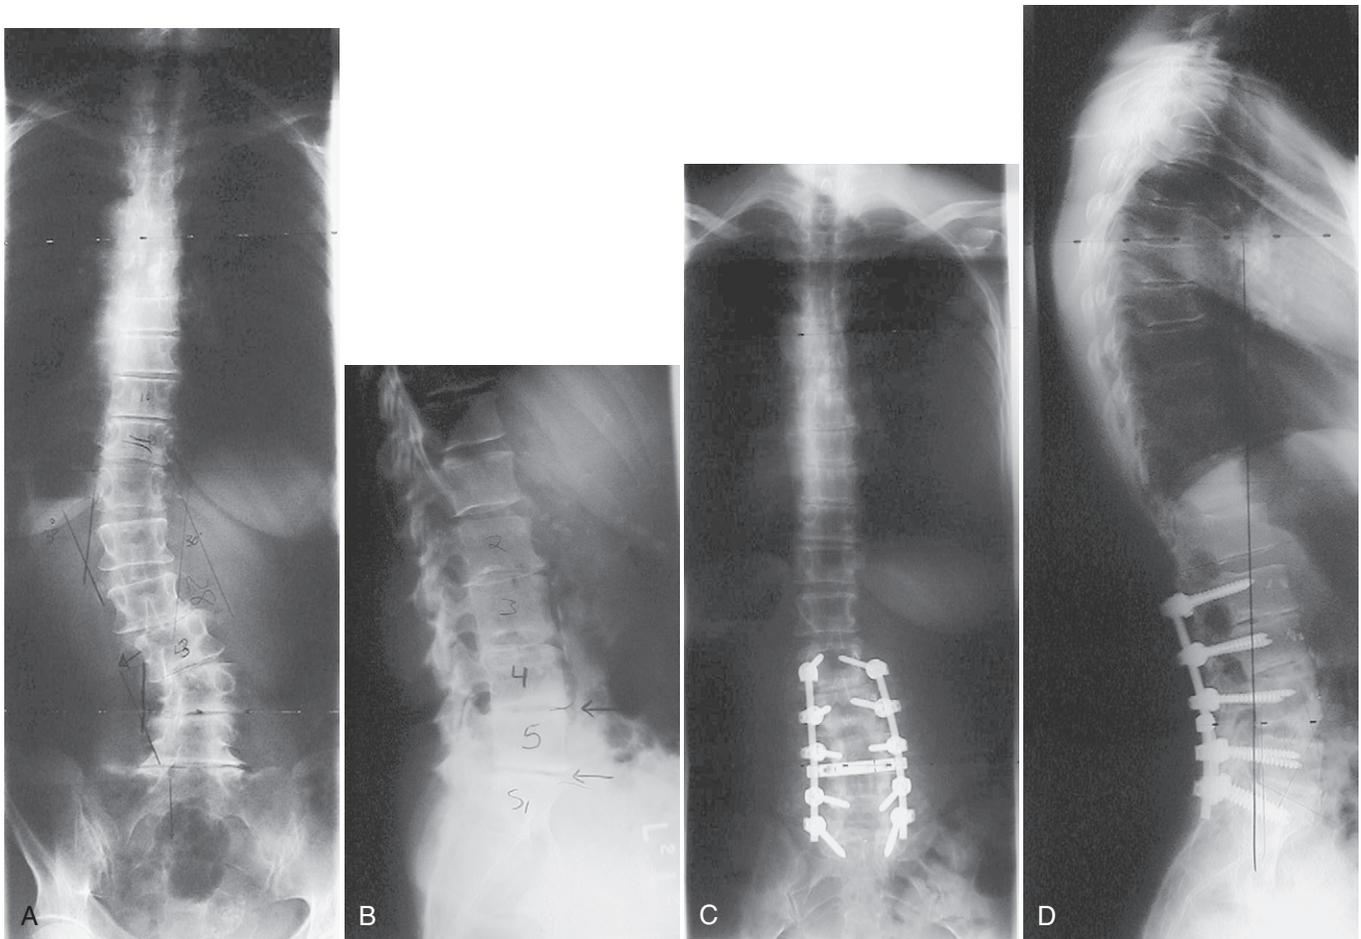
A 64-year-old woman with degenerative scoliosis and disabling low back and radicular leg pain. A, AP radiograph demonstrates severe lateral listhesis at L2–L3 and L3–L4 resulting in symptomatic compressive neuropathy. B, Lateral radiograph demonstrating severe disc degeneration and consequent loss of lumbar lordosis. She was treated with anterior–posterior fusion, instrumentation, and decompression. C, AP radiograph demonstrates correction of lateral listhesis and tilt. D, Lateral film shows excellent restoration of lumbar lordosis with structural interbody allograft.
